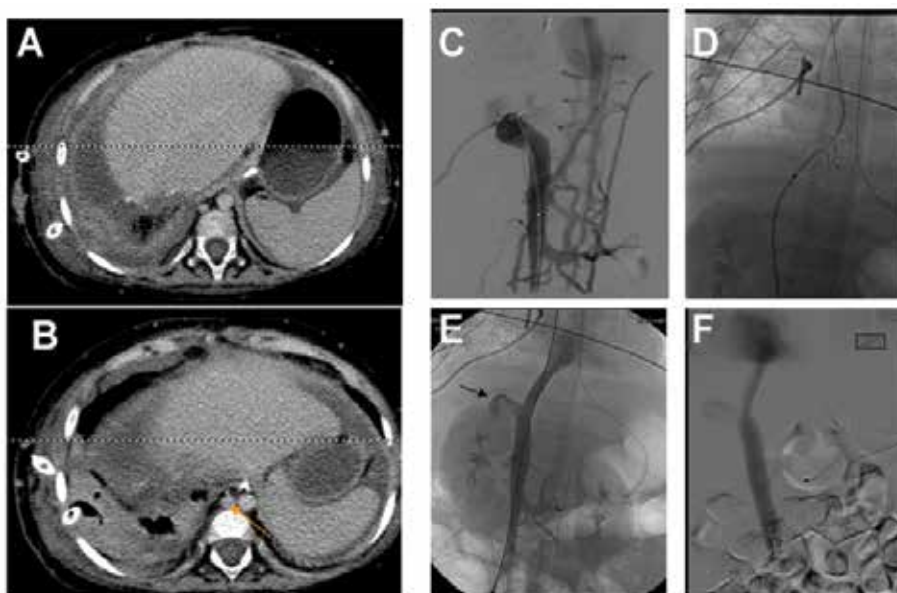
Management of IVC occlusion. (A&B) CT scan of the upper abdomen demonstrating absence of the suprahepatic IVC in (A) and congested azygos vein (arrow) in B. (C) Initial cavogram confirms the occlusion of the IVC with opacification of the azygos system. (D&E) Successful recanalization and stenting of the IVC. The arrow in E points to the piggyback stump. (F) Follow up cavogram after six months confirms the patency of the stented IVC
